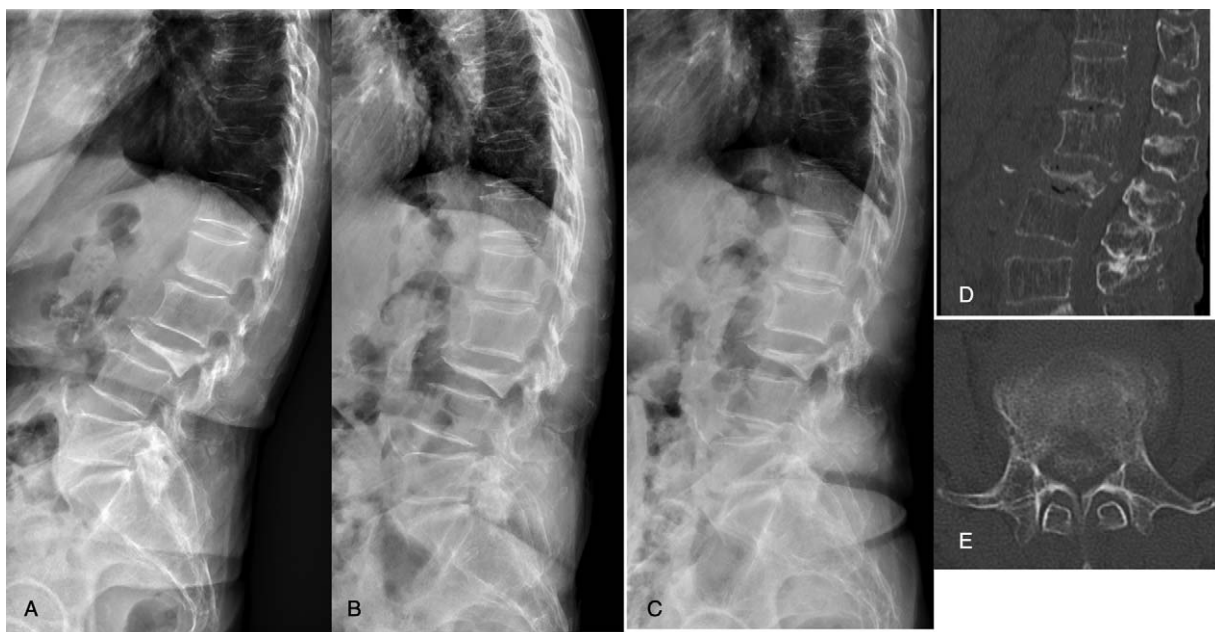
A 82-year-old female patient who underwent anterior and posterior combined surgery for L3 osteoporotic delayed vertebral collapse. Lateral view of thoracolumbar and lumbar radiogram taken in neutral position (A), flexion position (B), and extension position (C) at baseline. The mid-sagittal (D) and axial (E) image of computed tomography reconstruction.
